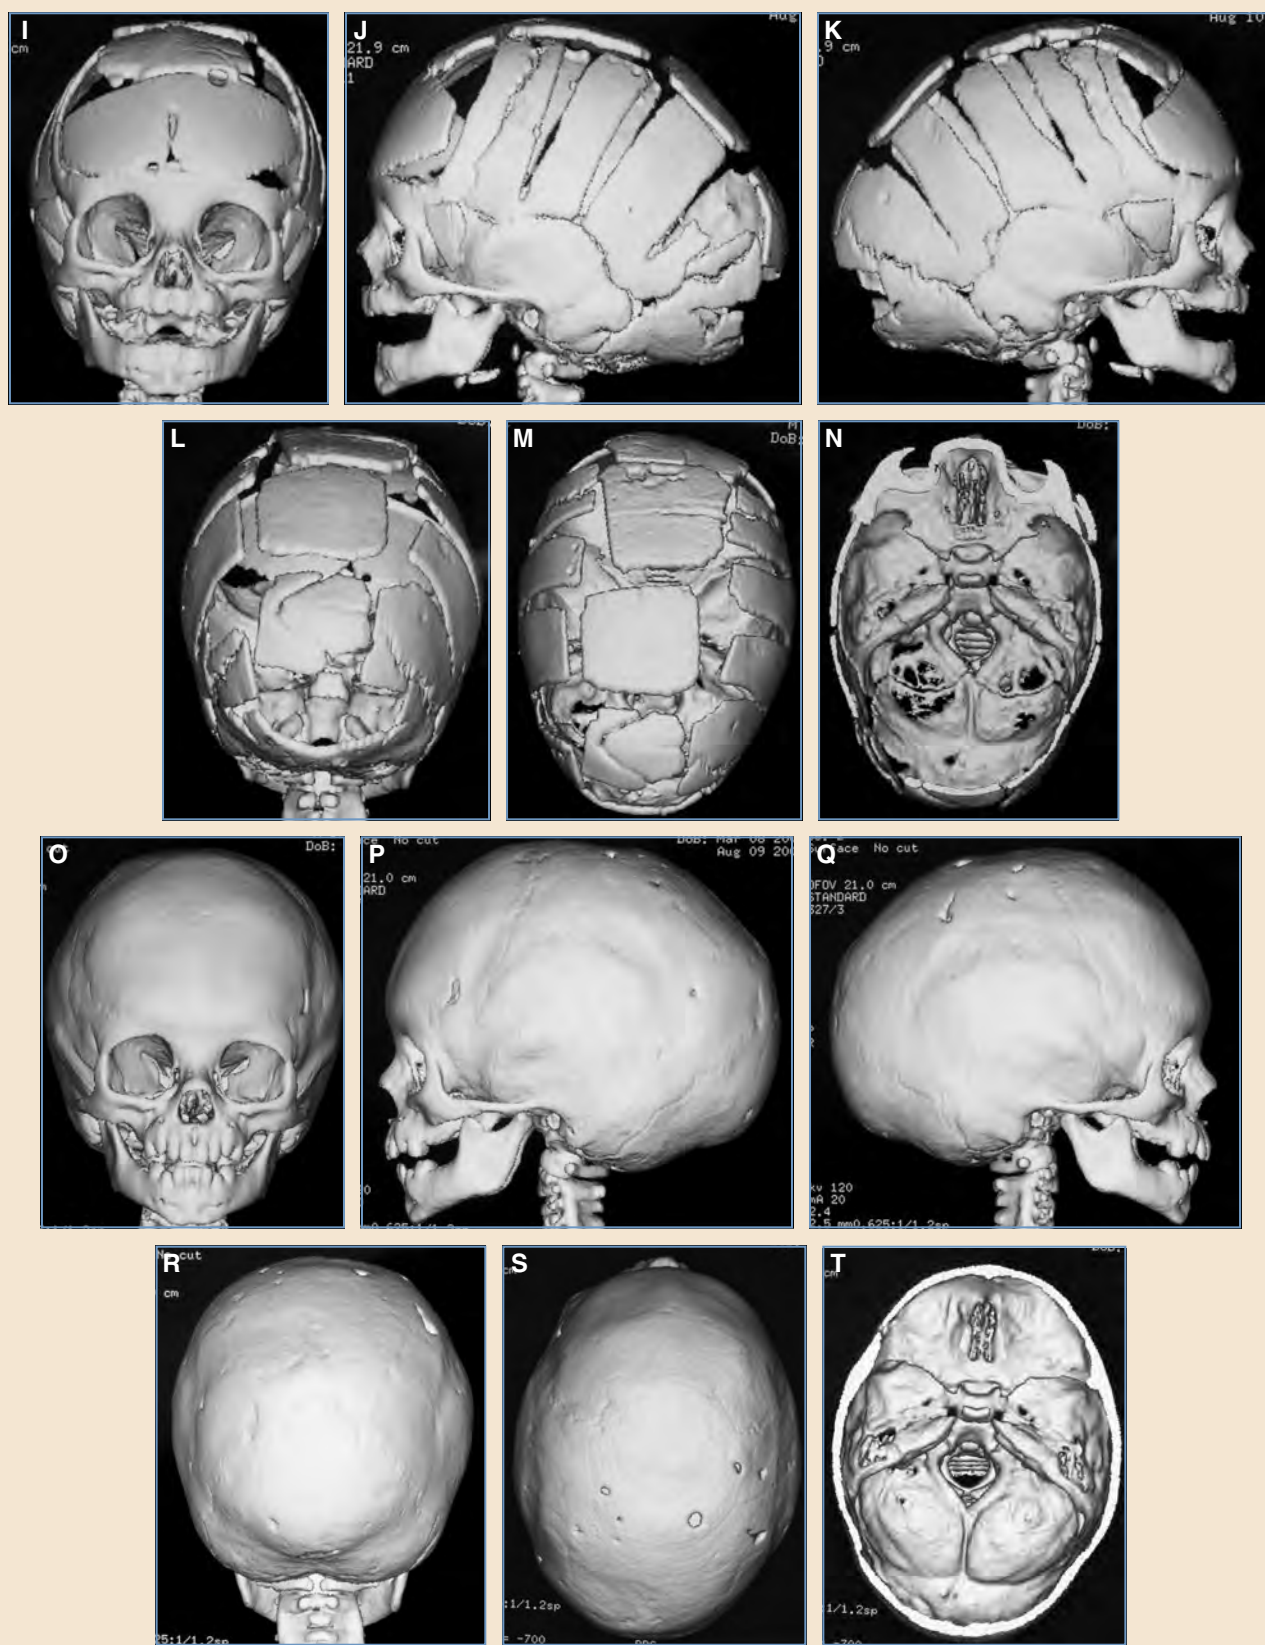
cont'd I-N, Immediately postoperative CT images. O-T, One year postoperatively, his cranial shape has normalized.
